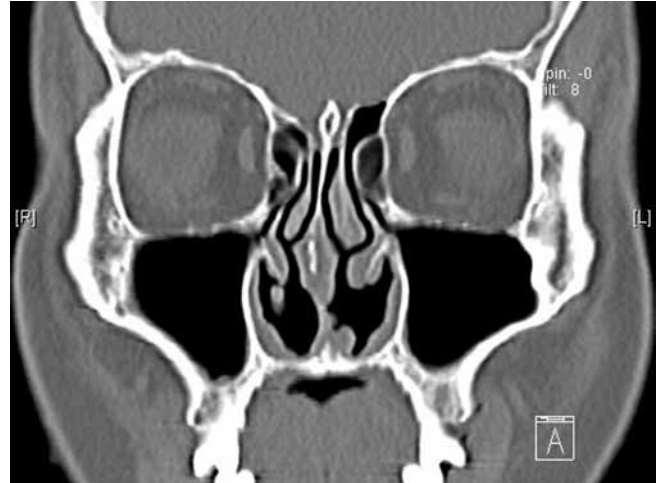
The sinus CT of an ENS patient who received previous inferior turbinectomy showed much widened common nasal cavity and inferior meatus.
